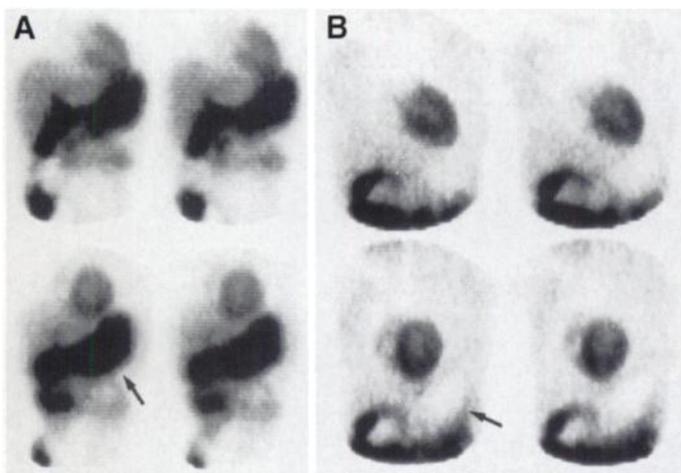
Marked enterogastric bile reflux in a 53-yr-old man with chest pain. Four projection images from a treadmill stress ^{99m}Tc -sestamibi SPECT study show (A) marked activity in the stomach (arrow) greater in intensity than myocardial uptake. A study 1 yr earlier (B) showed the stomach as a relatively photon-deficient area (arrow) with no evidence of EGBR.
